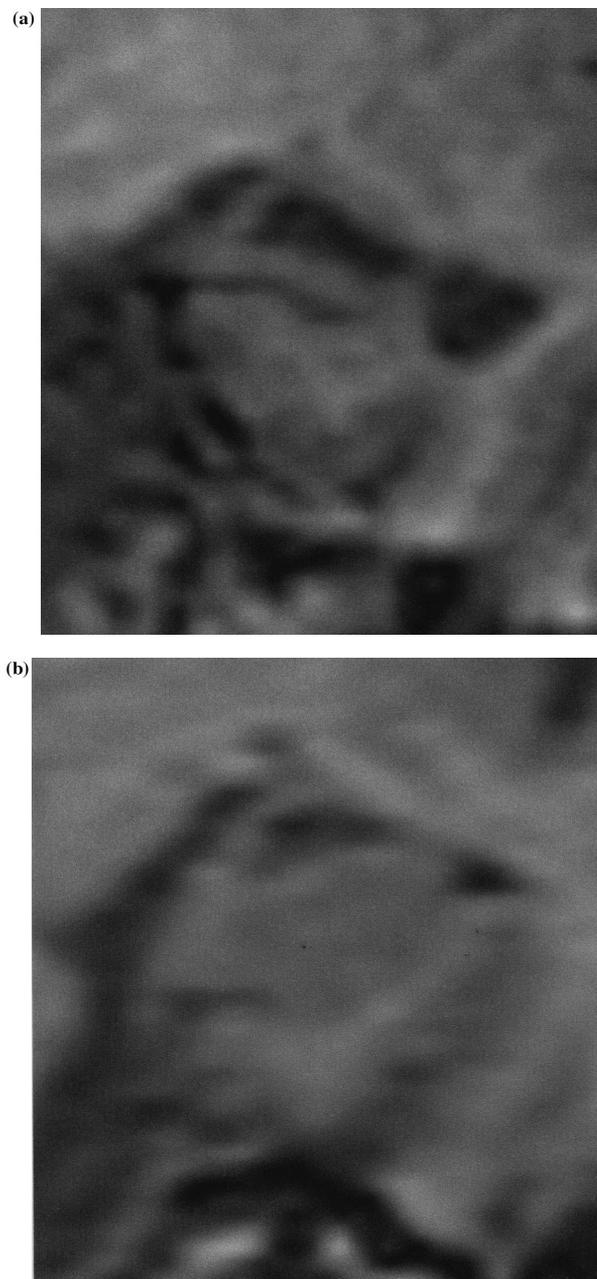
Coronal sections through the head of the left hippocampus of VC (a) and the control subject (b) (T1-weighted MRI). In VC there is a near total destruction of the hippocampus (consisting primarily of the CA1 field) superior to the uncal sulcus.
